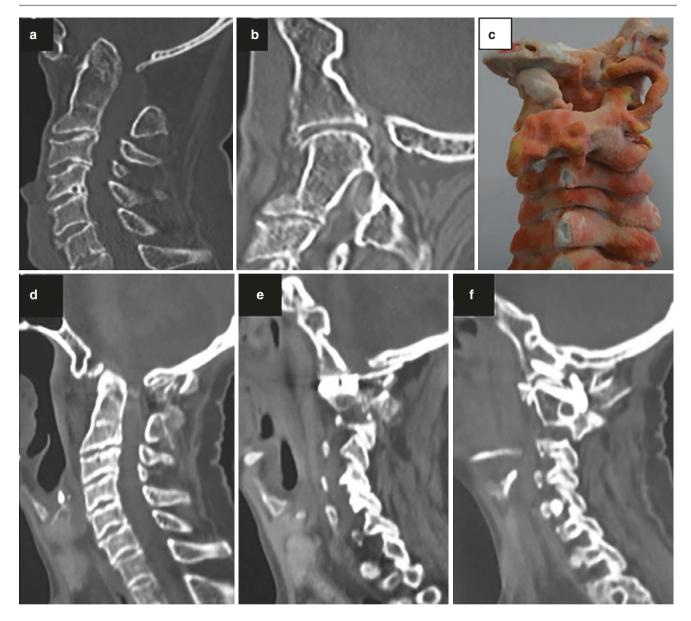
Imaging findings in a 52-year-old woman. Preoperative computed tomography (CT) shows basilar invagination, assimilation of the atlas, and C2–C3 fusion (a), and evidence of instability-related osteophytes (b; sagittal cut through the facets). A three-dimensional model demonstrates the anatomy of the region (c); osteophytes can be seen
